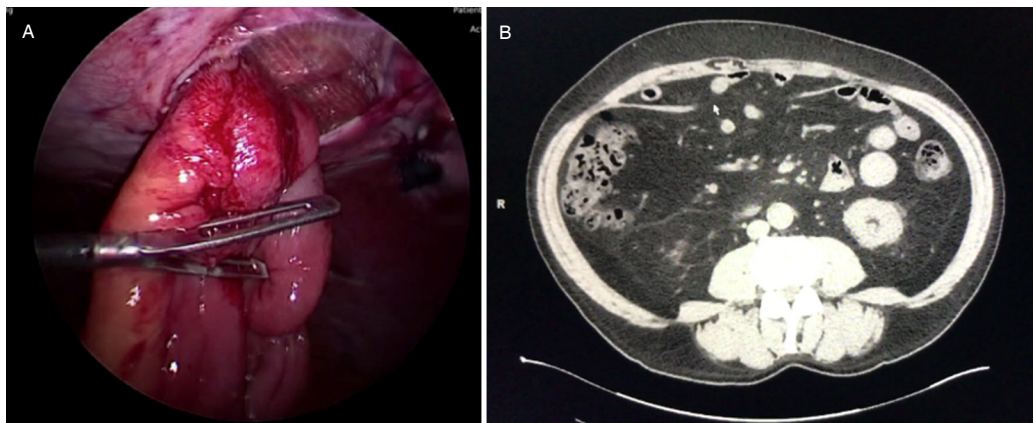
A: laparoscopic image of bowel herniated above the posterior rectus sheath and in contact with the exposed mesh. B: CT image showing the dehiscence posterior rectus sheath with bowel herniated above. Linea alba is intact with no full thickness herniation
